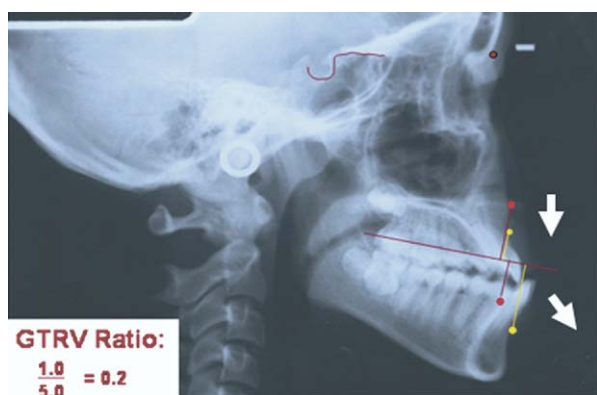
First tracing was superimposed on follow-up radiograph by using stable landmarks on midsagittal cranial structure. Distance between A-point of 2 tracings along occlusal plane represents growth changes of maxilla, and distance on occlusal plane of B point represents growth changes of mandible. GTRV ratio was then calculated.
